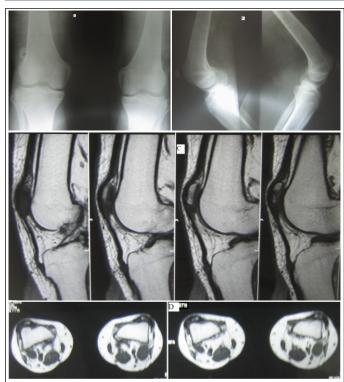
[A] X-ray Anterior posterior view of knee joint, [B] X-ray lateral view of knee joint, [C] MRI of knee joint sagittal section, [D] MRI of knee joint transverse section, [E] Clinical photograph
